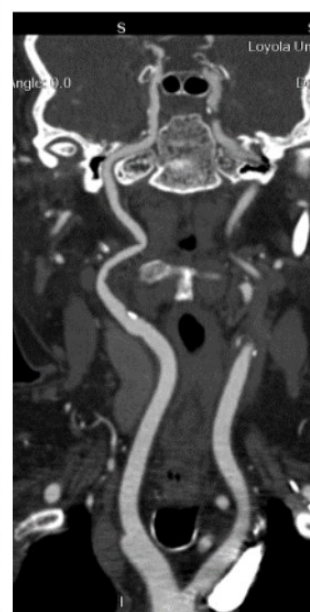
CT Head and Neck angiogram of Right Internal carotid artery Curved AP view. There is moderate to severe stenosis involving the supraclinoid portion of the right internal carotid artery with reconstitution of the caliber distally at the carotid apex
